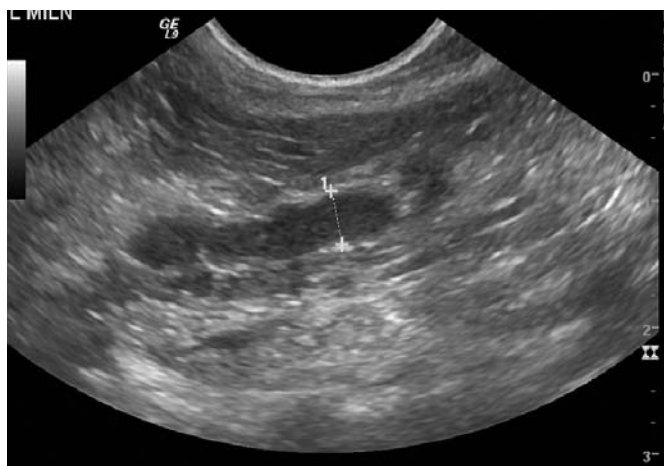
Enlarged left medial iliac lymph node chain with surrounding hyperechoic fat detected by abdominal ultrasound at routine staging of an 11-year-old female neutered (FN) Abyssinian with mammary carcinomas of the left caudal abdominal and right cranial thoracic glands
